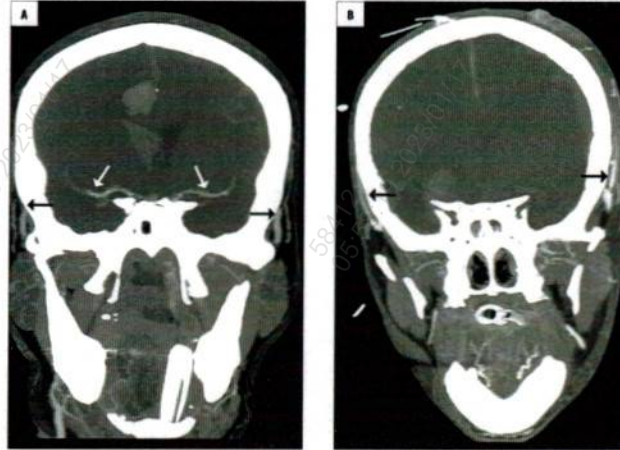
Positive results of CTA in the diagnosis of brain death where A coronal MIP demonstrates stasis filling with delayed opacification of proximal MCAs (white arrows). The superficial temporal arteries (black arrows) are opacified. B shows no intracranial filling. These findings confirm the diagnosis of brain death.
